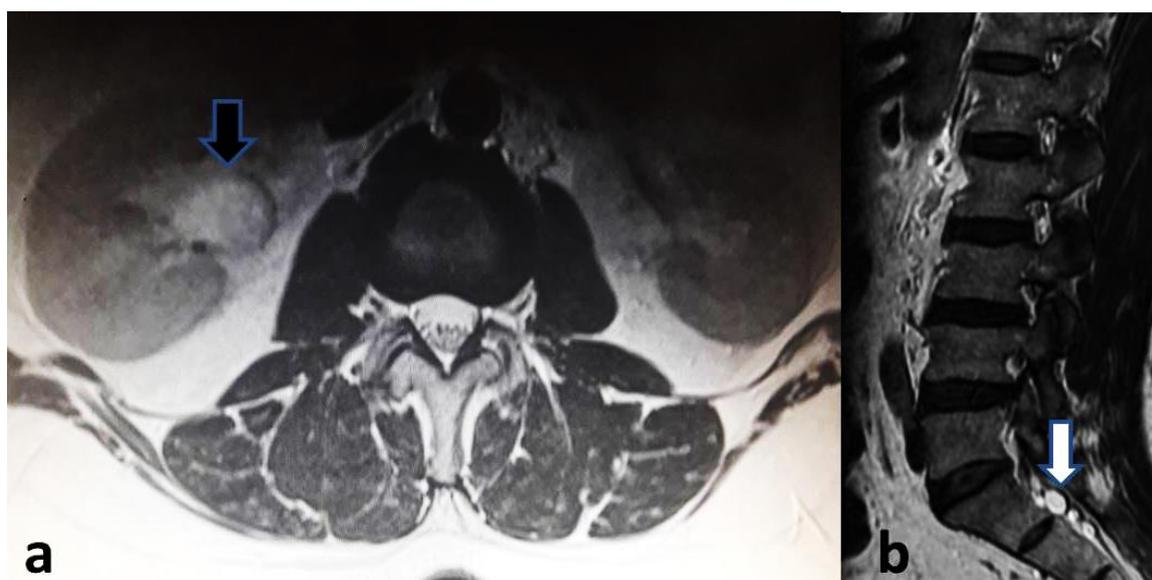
(a) Lumbar MRI (T2) at weighted axial section, right calyx cystic lesion detected (black arrow), (b) Lumbar MRI (T2) at weighted sagittal section sacral region, arachnoid cyst (tarlov cyst) detected (white arrow)
